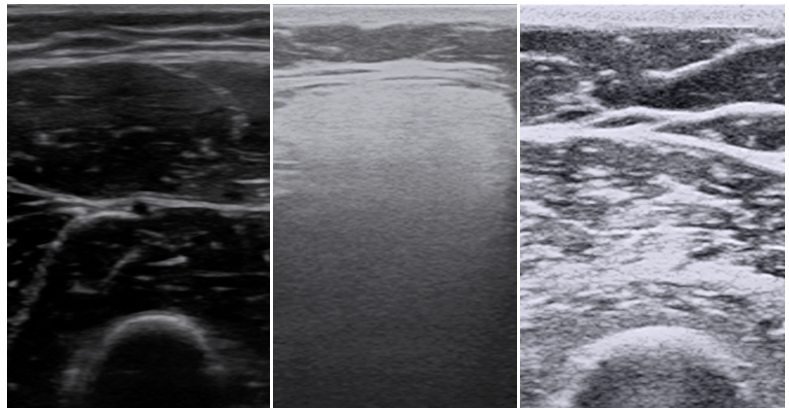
The left panel shows ultrasound of a normal quadriceps muscle with a typical starry night pattern. The middle panel is ultrasound of quadriceps in a patient with severe myopathy showing increased echogenicity with a ground-glass pattern. The right panel shows ultrasound of biceps in a patient with severe chronic denervation with evidence of patchy increase in echogenicity throughout the muscle.
